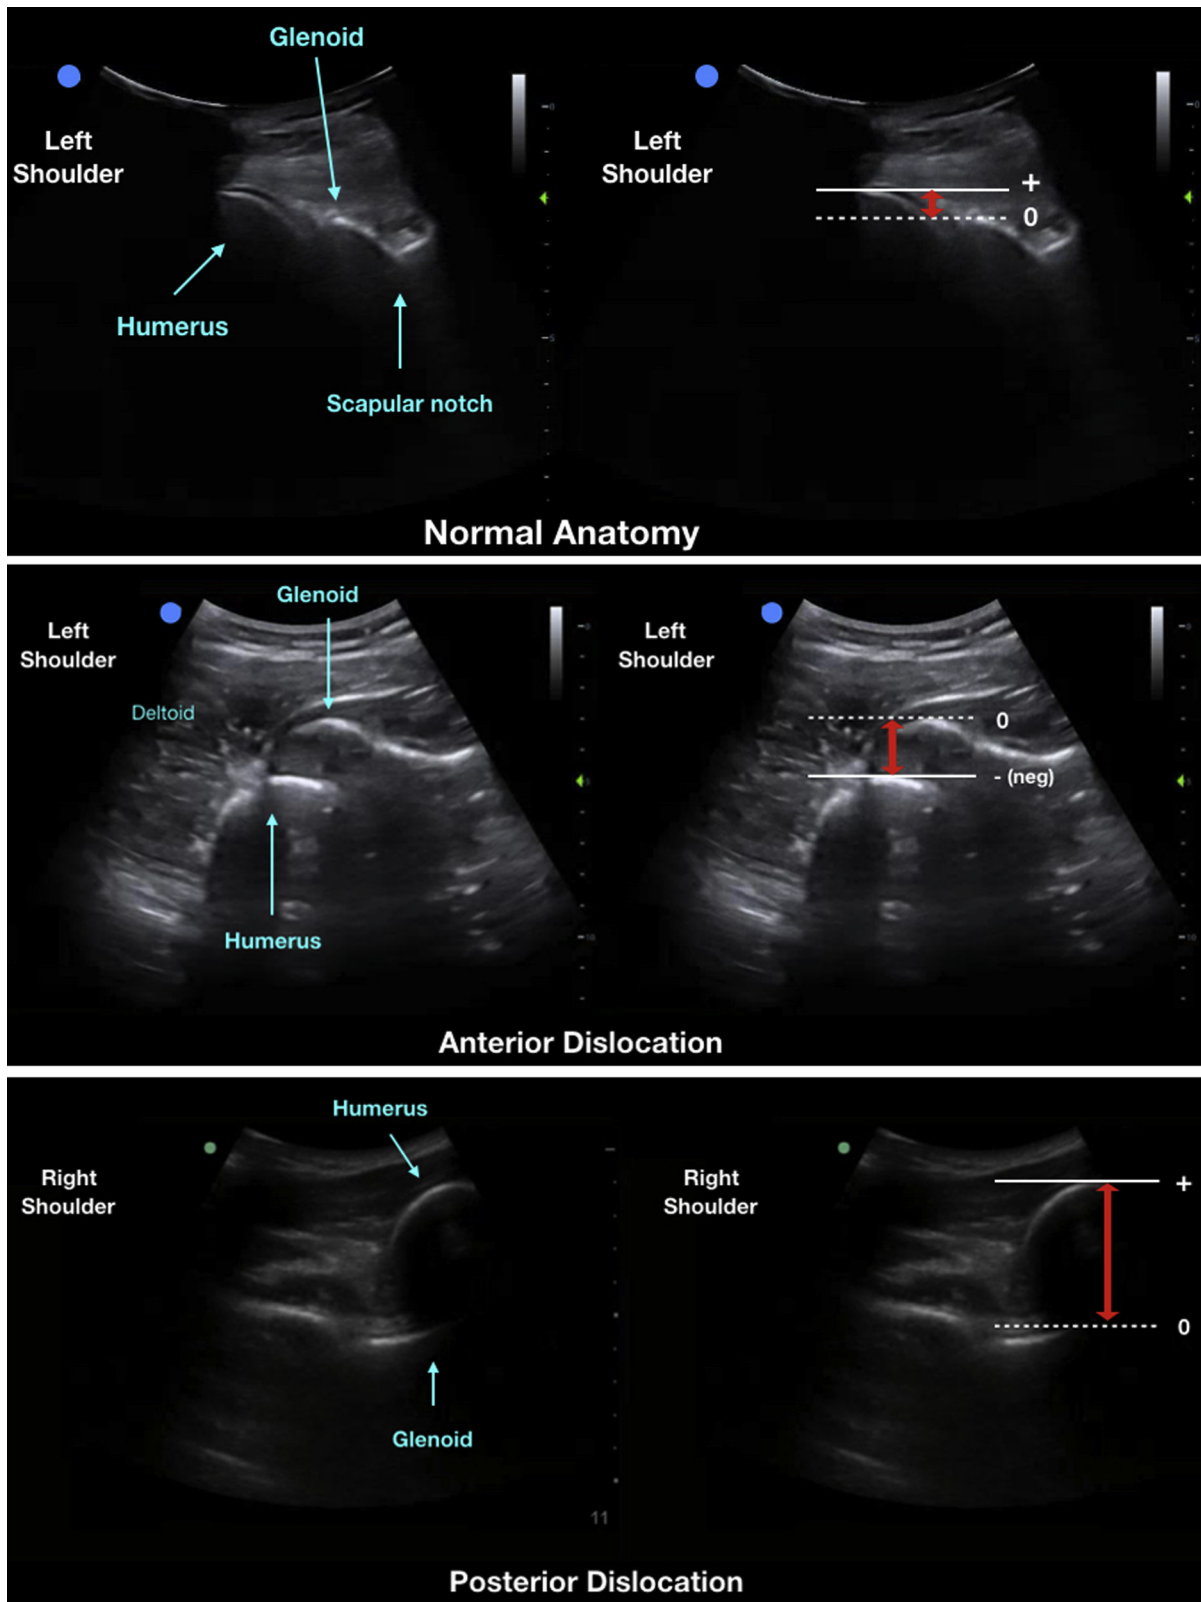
Ultrasonographic images of the shoulder girdle, using a curvilinear probe demonstrating the normal anatomy of the left glenohumeral joint (A), a left anterior dislocation of the shoulder with humeral head displaced anterior to the glenoid (B), and a right posterior shoulder dislocation with the humerus displaced posterior to the glenoid (C). The adjacent images correspond to the measurement of the glenohumeral distance, indicated by the red arrows.
